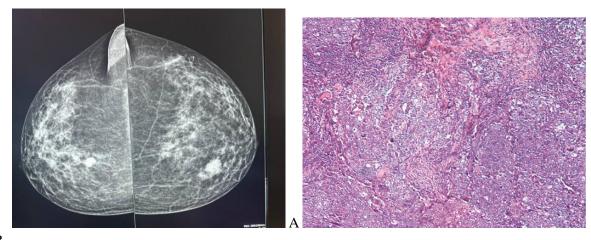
Patient R, 45 years old. A – X-ray mammography is imaged in two projections. In the center of the right mammary gland, an uneven inhomogeneous shadow with a contour of 91x85.5 mm was detected. BI-RADS R - 4b.
